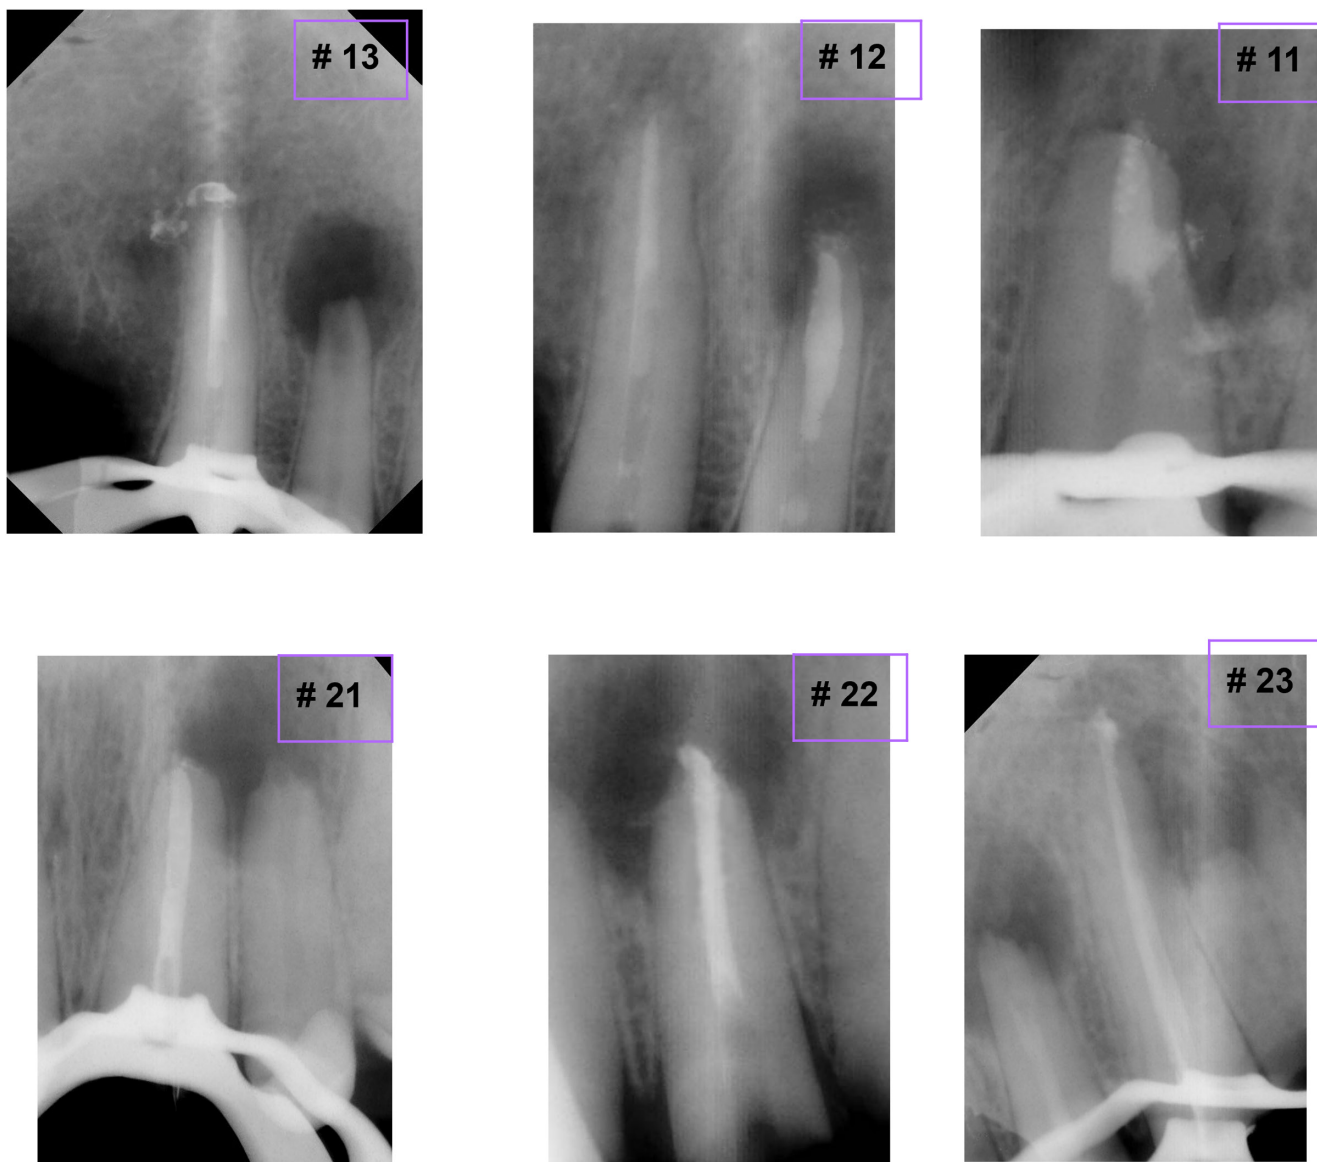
Periapical radiograph showed conventional root canal obturation with warm vertical compaction using heat carrying instrument (System B) for #13 and 23, Customized gutta-percha for #12, 11, 21, and 22 and thermo-plasticized gutta-percha (Obtura II) for #12.
